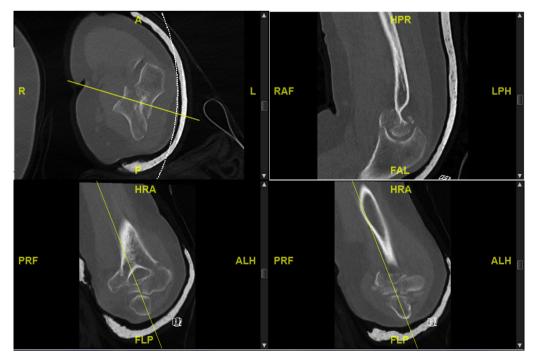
Midsagittal CT scan of a typical type C distal humerus fracture with significant articular comminution.
